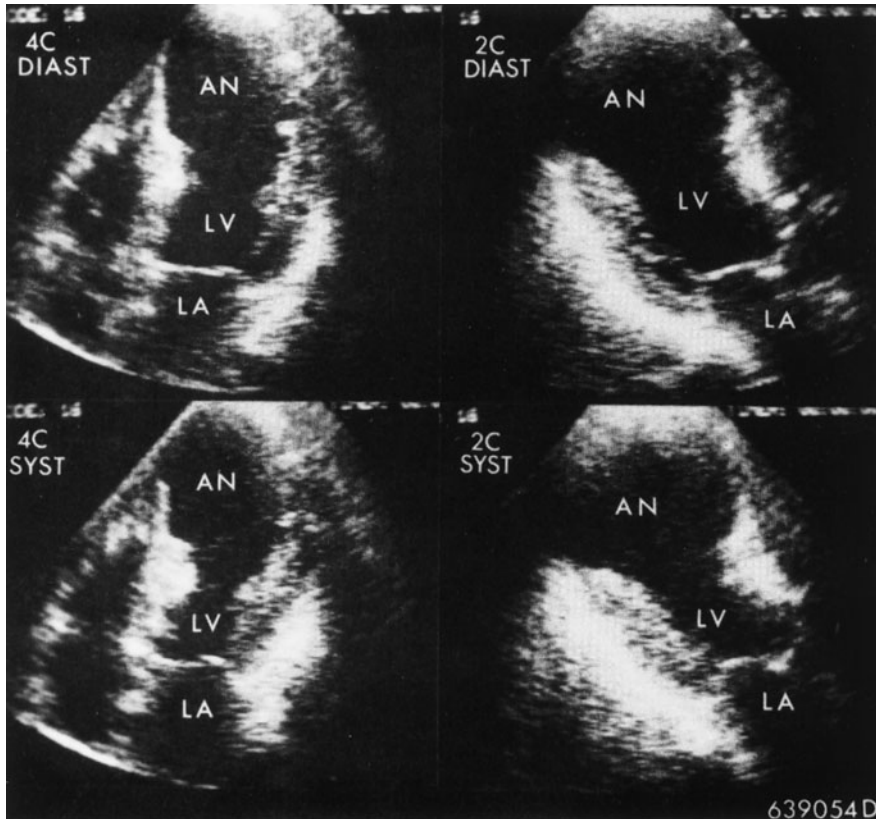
Four-chamber (4C) and two-chamber (2C) two-dimensional echocardiograms demonstrating a left ventricular aneurysm (AN) during systole (SYST) and diastole (DIAST). (LV = left ventricle; LA = left atrium.) (Reproduced with permission from Feigenbaum H: *Echocardiography*. Philadelphia, Lea & Febiger, 1986; p 484.)
